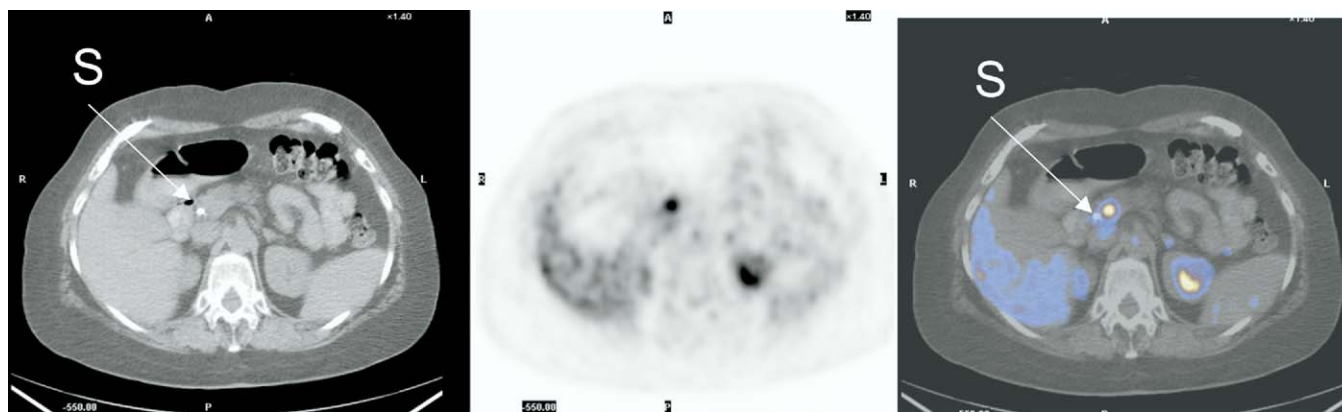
A 70-year-old woman presented with painless obstructive jaundice and negative ultrasound and CT findings. An ERCP suggested a short stricture of the distal common bile duct and a biliary stent was inserted. The FDG PET/CT shown above, demonstrates a lesion in the head of the pancreas, adjacent to the biliary stent (S). Anatomical localization of the PET-positive lesion directed further imaging with EUS and a biopsy, which confirmed the diagnosis of pancreatic adenocarcinoma.
